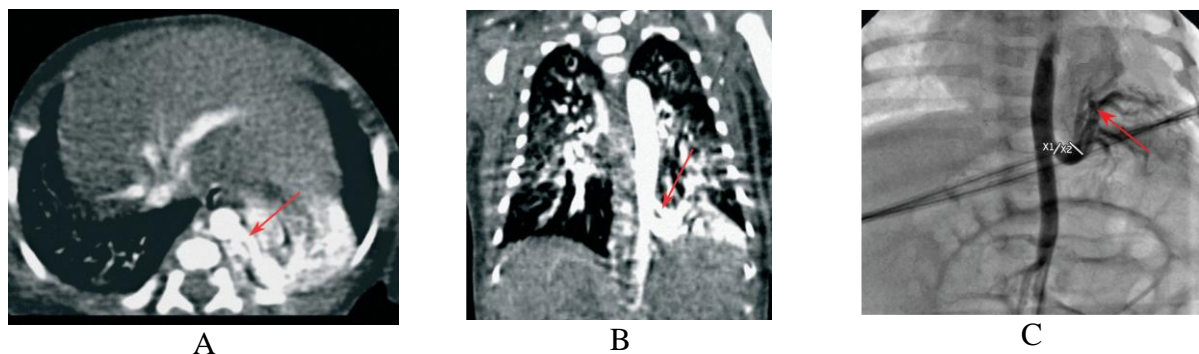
Contrast enhanced chest CT (A, B) and angiography (C) in newborn patients with intralobar sequestration of the left lung (age 7 days and 1 month respectively). A — CT, axial scan. B — frontal reconstruction. Arrows indicate aberrant vessels originating from the thoracic aorta and extending to the left lung sequester. C — angiography. The big arterial vessel (arrow) originates from the abdominal aorta and provides blood supply of the sequester of the left lung
